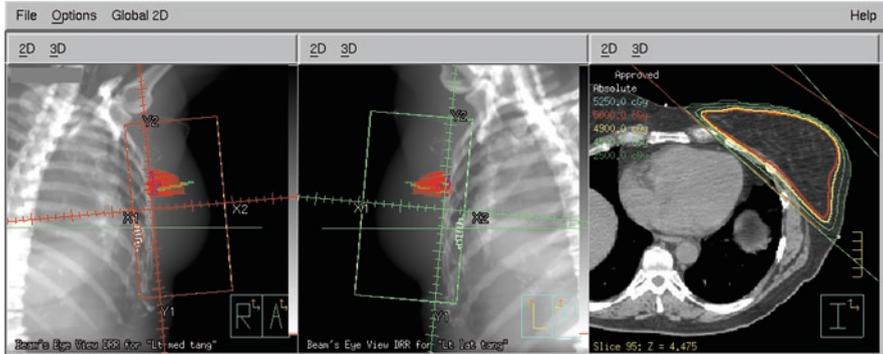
Field boundaries for a 56-year-old woman with a pT1b, N0 (sn)(i)-, M0 invasive ductal carcinoma of the left breast who underwent lumpectomy. A cardiac block was placed on both the medial and lateral tangent fields to block the heart out of the field while still allowing good coverage of the surgical bed and clips. The axial view is at the level of the cardiac block, as shown in the medial and lateral digitally reconstructed radiograph views
